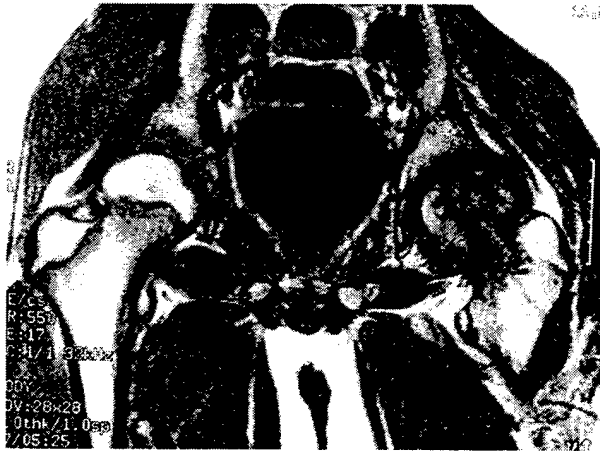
MRI demonstrating edema in the femoral head and metaphysis, and acetabulum. Fracture healing is confirmed. Destructive changes are obvious in the femoral head. Signal in femoral head and acetabulum is not indicative of infection.
